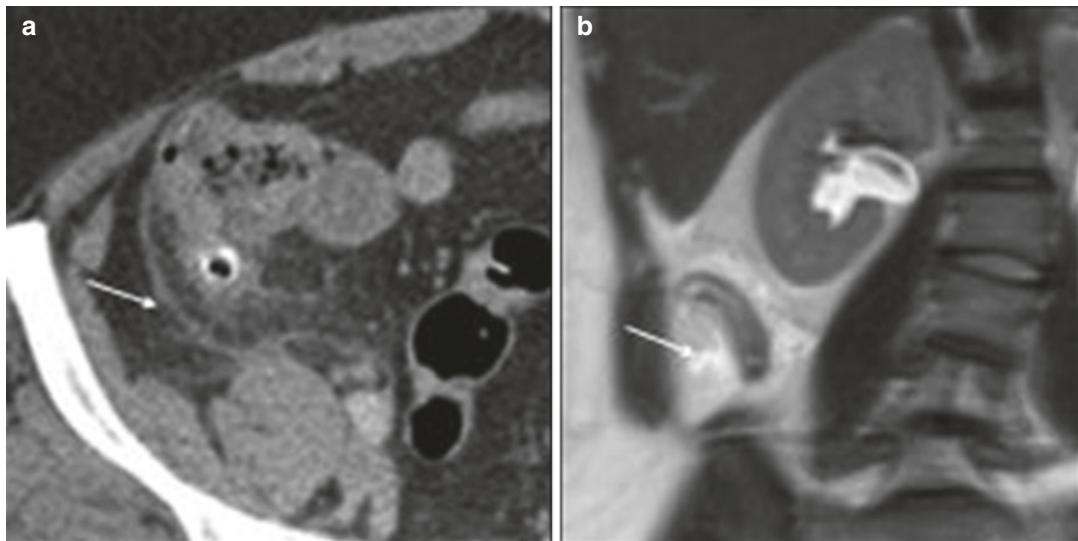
Fat stranding (arrows), a common sign of inflammation, as seen on an axial abdominal CT image (a) in a 40-year-old woman with cecal diverticulitis. On MRI
